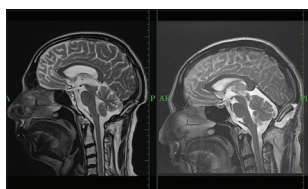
Right: Presurgery: A circumscribed lesion with well-defined margins is seen involving the pineal gland, which has mixed intermediate and high signal on sagittal T2-weighted images. Left: Postsurgery/postchemotherapy/radiotherapy: Evidence of craniotomy and postoperative defect is noted in occipital bone. No altered signal intensity lesion is appreciated
